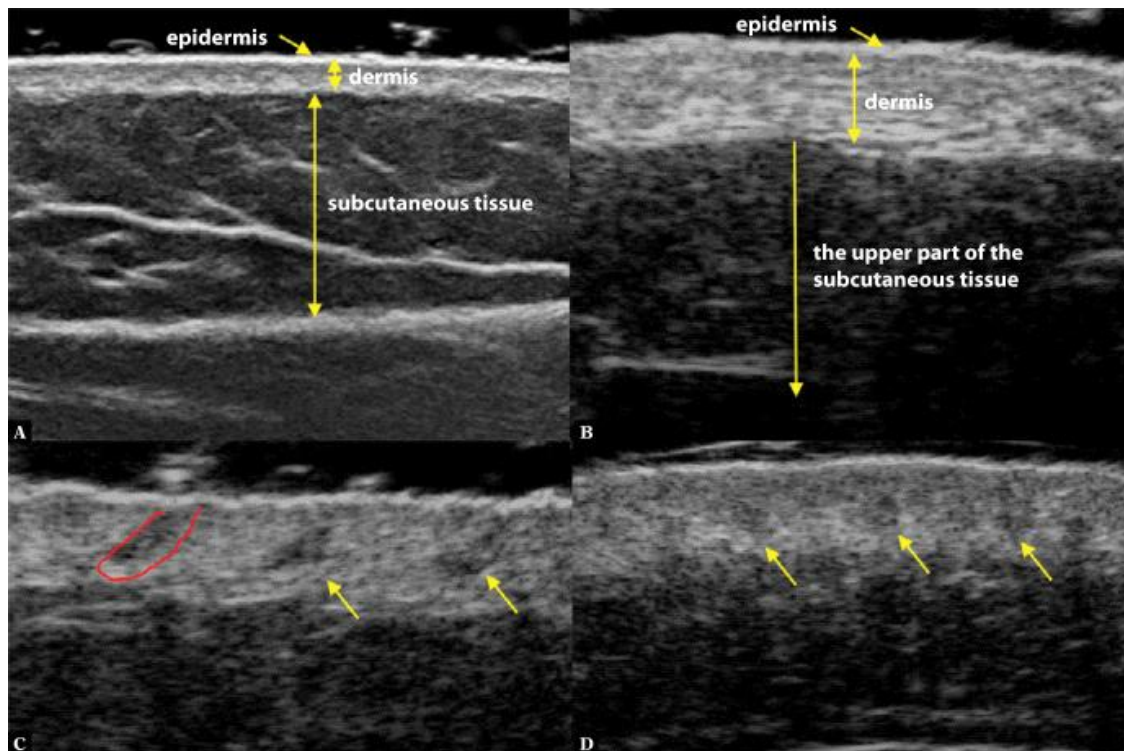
The figure presents the ultrasonographic image of healthy skin:
